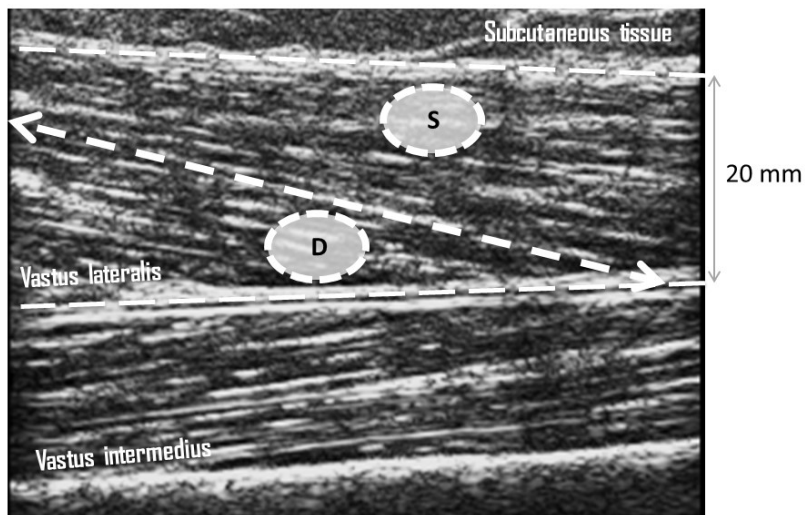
Ultrasound image showing vastus lateralis and intermedius around the proximal VL motor point. The superficial and deep VL aponeuroses and a fascicle have been highlighted as white dashed lines. The superficial (S) and deep (D) iEMG target-sampling areas are indicated as pale shaded areas.
